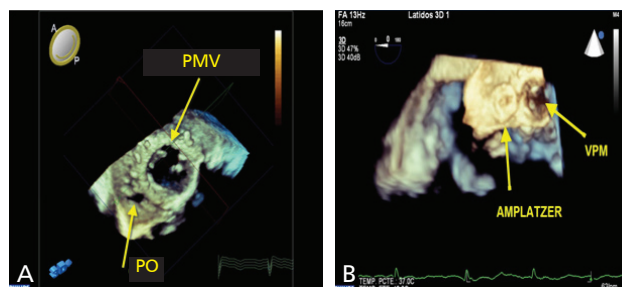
A Mitral paravalvular leak. A. Three-dimensional echocardiographic image of the prosthetic mitral valve (PMV) and the paraprosthetic orifice (PO) responsible for the leak. B. Left: Final x-ray image of the deployed Amplatzer® device. Right: Three-dimensional echocardiographic image of the deployed Amplatzer® device (top view).
